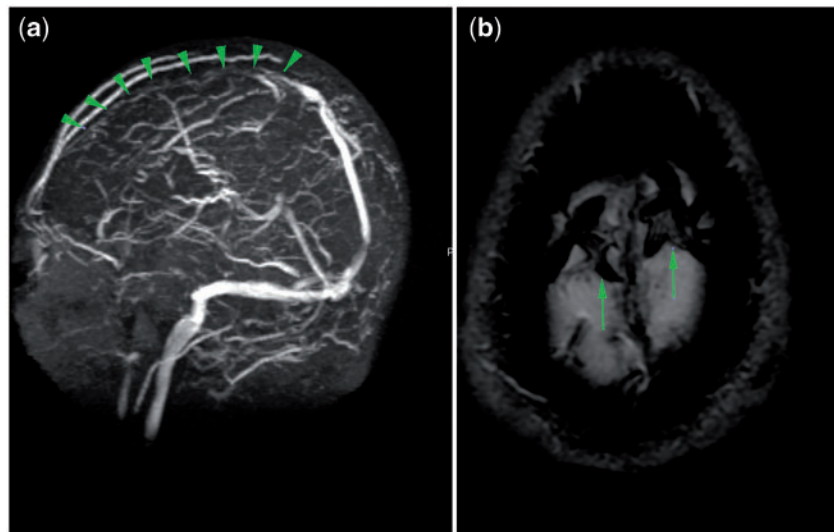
Left (a)—Coronal magnetic resonance venography reveals loss of vascular flow signal in the superior sagittal sinus and the bilateral superficial cortical veins in the frontal and anterior parietal lobes (arrowheads). Right (b)—Axial gradient-echo magnetic resonance image of the superior aspect of the brain demonstrates 'blooming' of the clot in the thrombosed superficial cerebral cortical veins (arrows).
